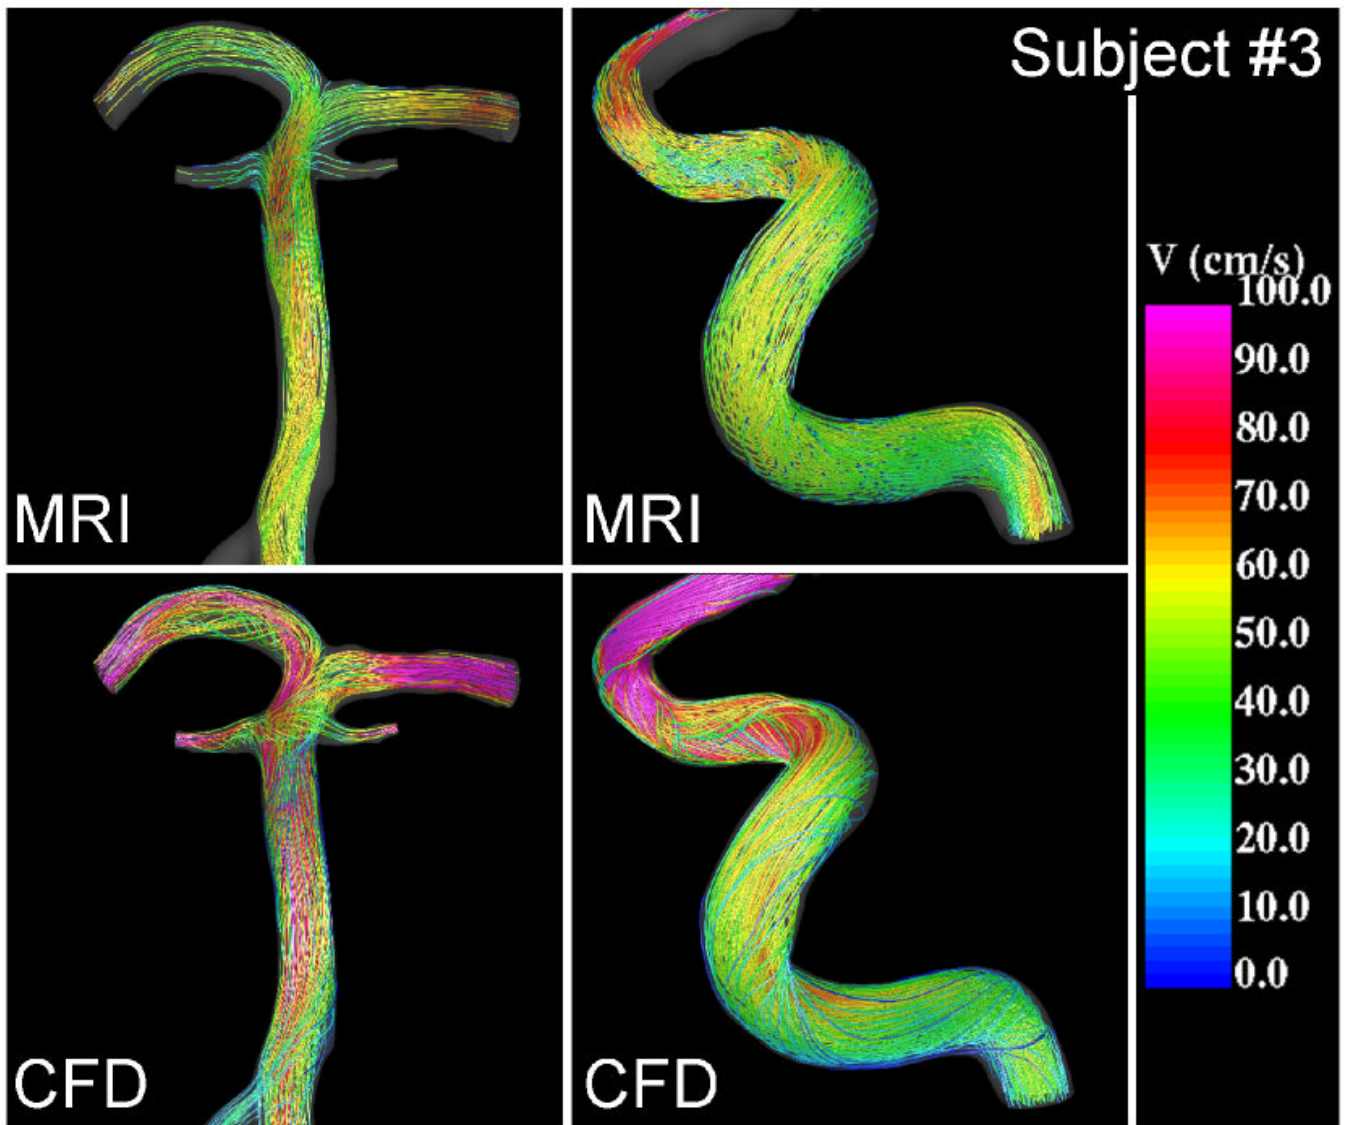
Visualizations of the blood flow patterns at peak systole in the basilar (left) and right internal carotid artery (right) of subject #3 obtained from the MRI (phase-contrast MR) data and CFD model.
